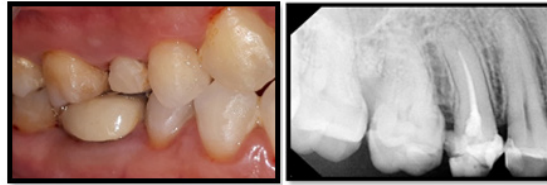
Preoperative view and intra oral periapical radiograph of tooth 15.
